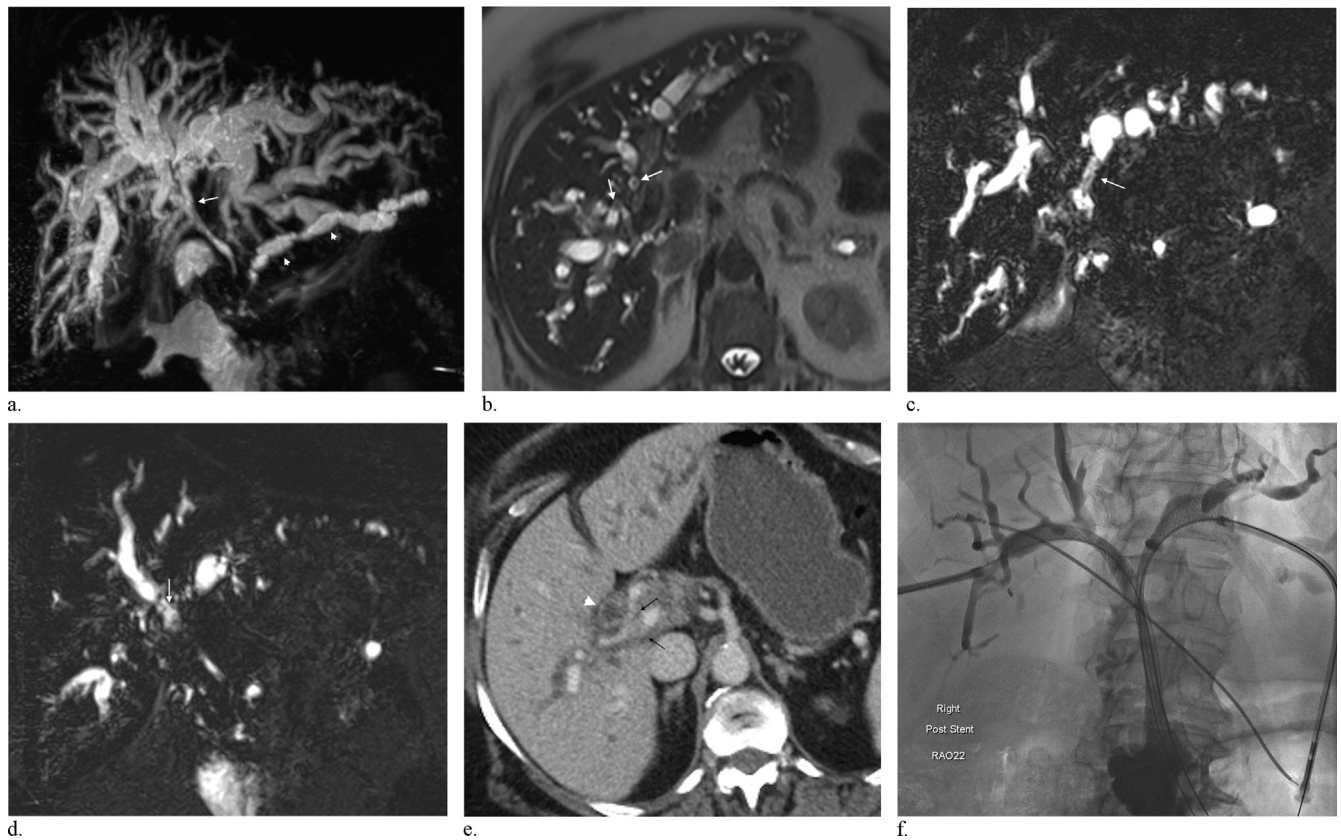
Images from a 65-year-old woman presenting with jaundice and pruritus. (a) Coronal T2-weighted MR cholangiopancreatography image demonstrates narrowing of the hepatic hilum (arrow) and intrahepatic bile duct dilation. The main pancreatic duct is also dilated mainly as a result of chronic pancreatitis (arrowheads). (b) Axial and (c,d) coronal T2-weighted images demonstrate disease extension to the bifurcation of the right and left hepatic ducts (arrows), consistent with Bismuth type IV disease. (e) Postcontrast CT demonstrates an ill-defined mass that infiltrated the hepatic artery (black arrows) and the PV (arrowhead). No significant nodes or metastases were detected, indicating stage IV disease (T4N0M0). Therefore, the tumor is considered inoperable. In view of the intrahepatic strictures, the patient underwent PTC and bilateral stent implantation. (f) PTC via bilateral percutaneous approach was performed, and two transpapillary 10-mm × 10-cm Wallstent stents (Boston Scientific, Marlborough, Massachusetts) were inserted, extending in the intrahepatic bile ducts. The percutaneous tracts were plugged with Gelfoam (Pharmacia & Upjohn, Kalamazoo, Michigan). The patient was discharged without complications, and chemotherapy was commenced.
